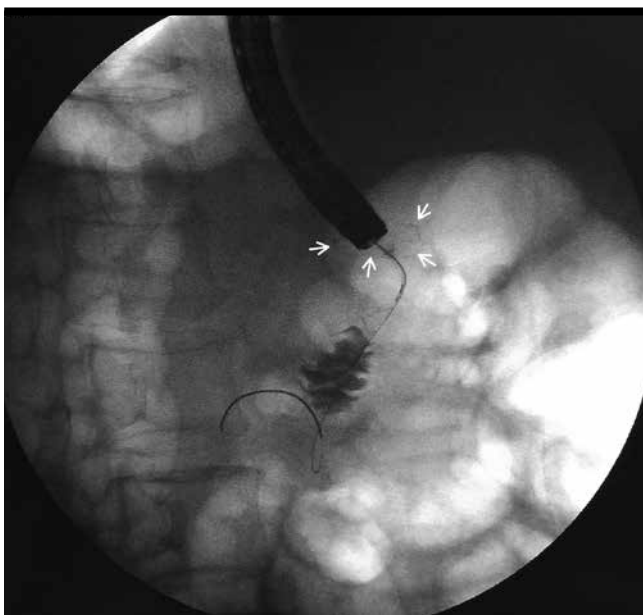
Dilatation of afferent loop revealed under X-ray after contrast agent injection. White arrow: ring-shaped anastomotic nail can be observed
